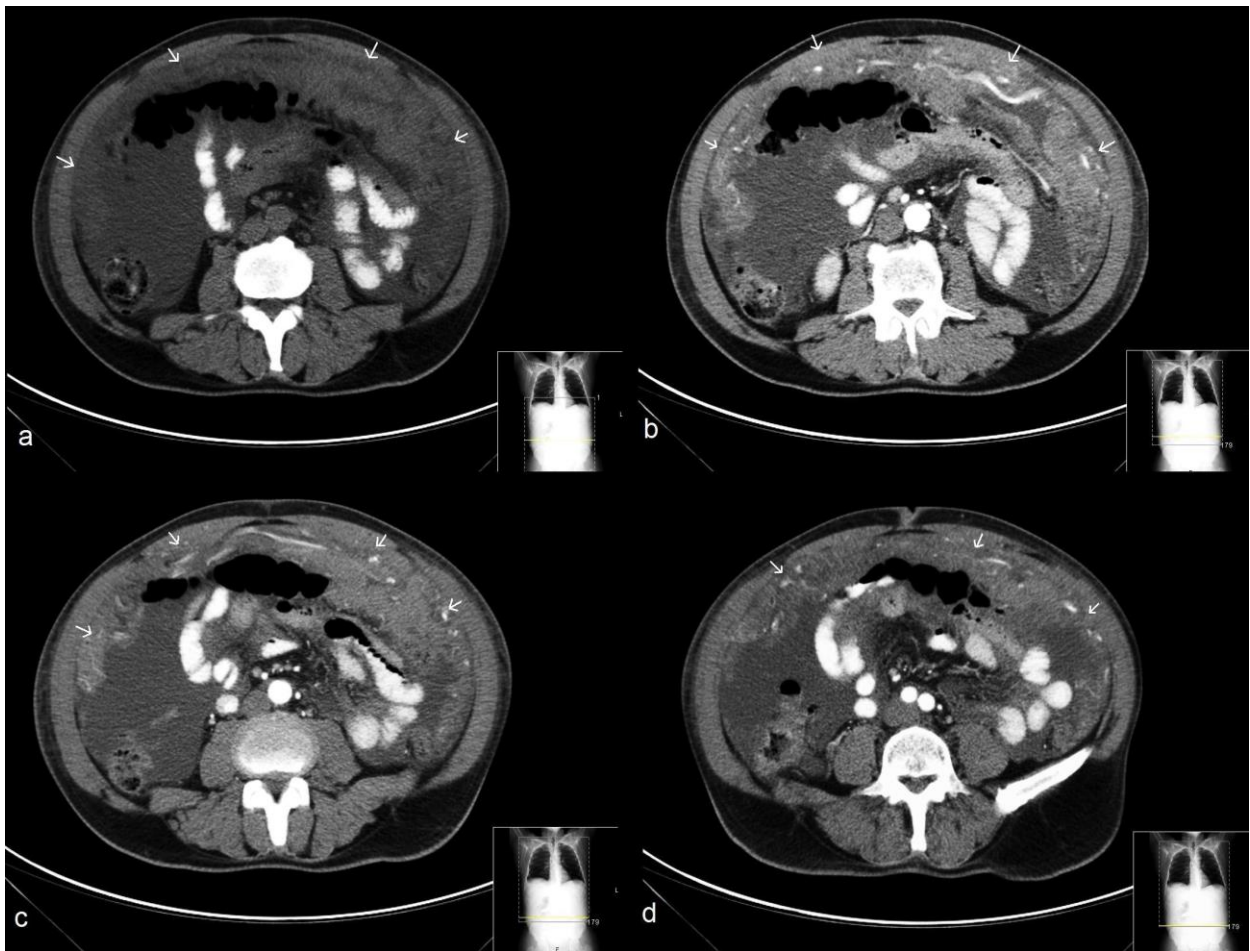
Sixty-one-year-old male with Burkitt lymphoma. Axial and plain contrast enhanced CT of the abdomen (Scanner: Multidetector CT Philips Brilliance 16- slices®. Protocol: 250mAs, 120kV, 5mm slice thickness, 100ml iobitridol Xenetix® (350 mg Iodine/ml)); a) Plain axial CT demonstrates diffuse thickening of the greater omentum, resulting in a large mass-like appearance with caking effect (arrows). Contrast enhanced CT in the arterial phase at different levels b), c) and d) reveals heterogeneous enhancement and a diffuse vascular net (arrows).
